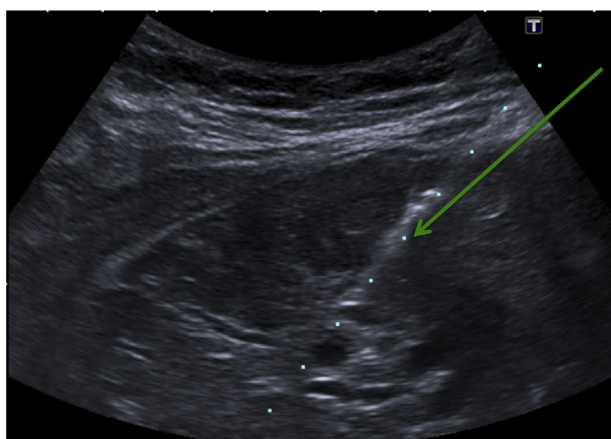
Ultrasound image of the biopsy needle passing through liver right lobe lesion (green arrow).
